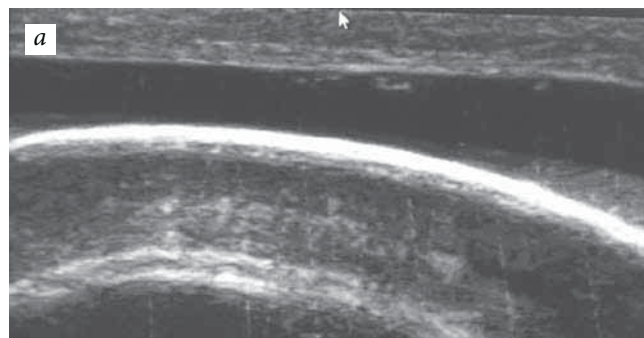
Ultrasonographic craniography in the cephalhematoma region: *a* — the norm, no fracture signs (bone continuity is not violated); *b* — signs of parietal bone linear fracture (bone continuity is violated, the “hyperechoic mark” phenomenon is immediately revealed under the fracture)
